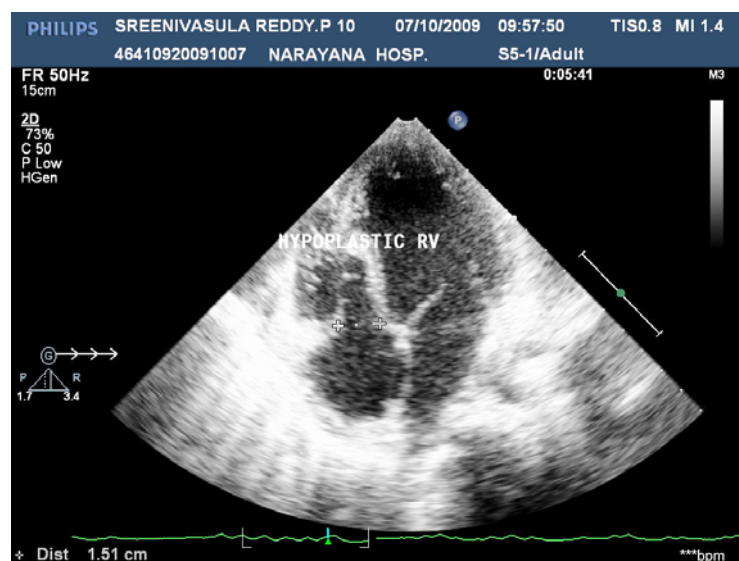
Echocardiography showing hypoplastic tricuspid valve and right ventricle.
